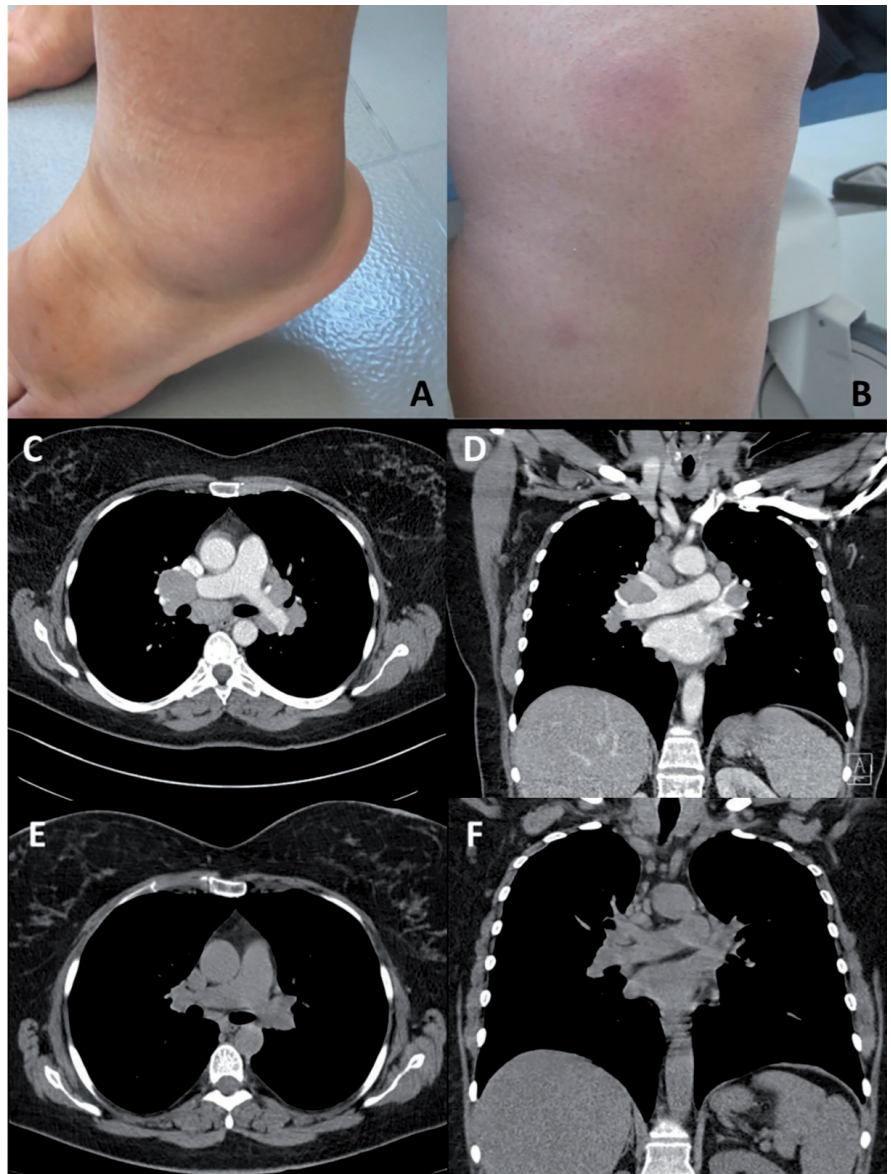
Ankle arthritis (bilateral) occurred (A), accompanied by erythema nodosum which was restricted to both lower legs and forearm (B). Contrast enhanced computed tomography showed bilateral hilar lymphadenopathy in axial and coronal slices (C and D). Regression of lymphadenopathy to near-normal size in the follow-up computed tomography without contrast after initiation of treatment (E and F).
